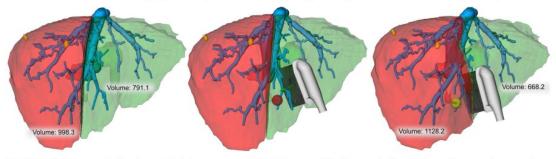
Left: Preoperatively planned right hepatectomy. The right part of the liver model (red) shows the parenchyma to be resected, while the left part is intended to remain. The yellow nodules represent segmented metastases. Middle: A new resection plane is defined with the ultrasound-based navigation system. The red sphere represents an intraoperative detected tumor. Right: The preoperative resection plane is merged with the resection plane defined intraoperatively and the volume calculation is updated.
